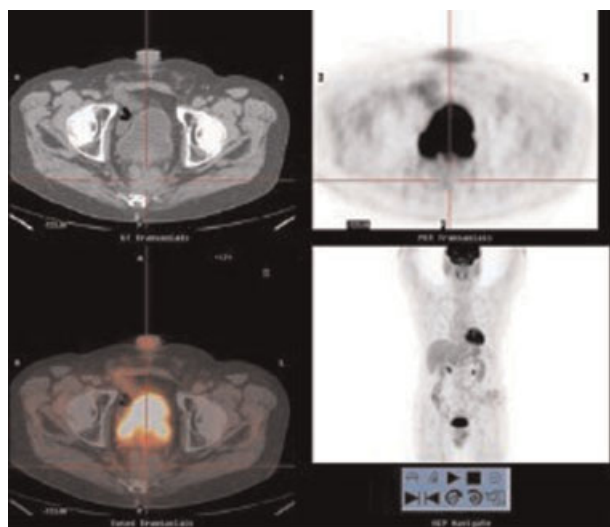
PET-CT. Patient with suspected presacral recurrence. PET-CT shows an ametabolic lesion that corresponds to fibrosis.
